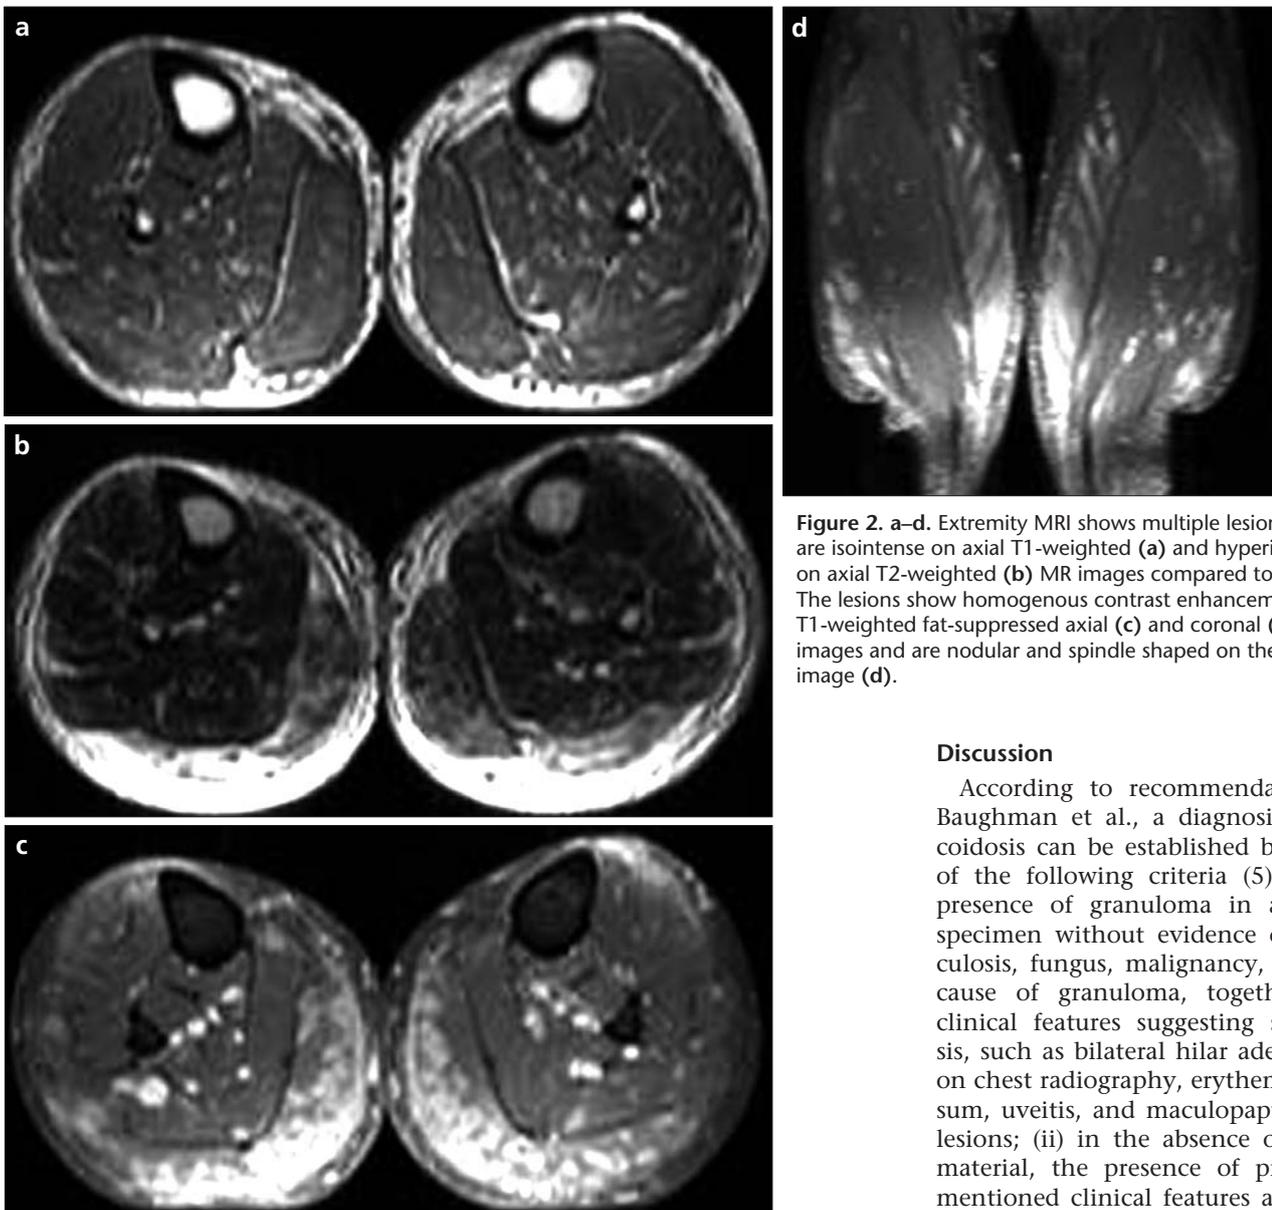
a–d. Extremity MRI shows multiple lesions which are isointense on axial T1-weighted (a) and hyperintense on axial T2-weighted (b) MR images compared to muscle. The lesions show homogenous contrast enhancement on T1-weighted fat-suppressed axial (c) and coronal (d) MR images and are nodular and spindle shaped on the coronal image (d).
